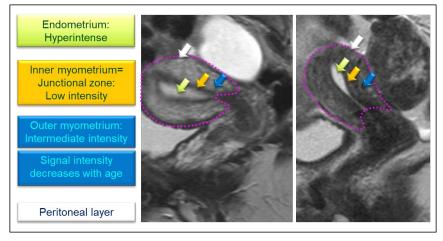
Uterine anatomy on pelvic T2w FSE MRI of two patients. Borders of normal uterus are depicted with magenta dotted line and zonal anatomy with arrows (color legend on the left). Note the conical shape of cervico-uterine border.
